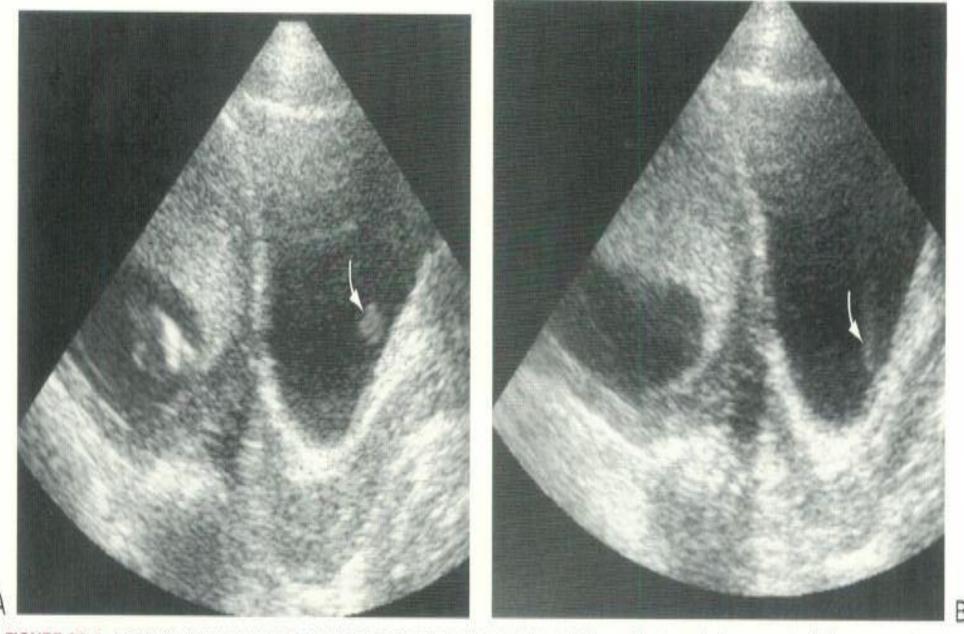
Longitudinal sonograms demonstrating the maternal urinary bladder and the gravid uterus. A. An apparent soft tissue mass is seen in the urinary bladder (arrow). B. In fact, this is the stream of urine entering the bladder through the ureteral orifice.
